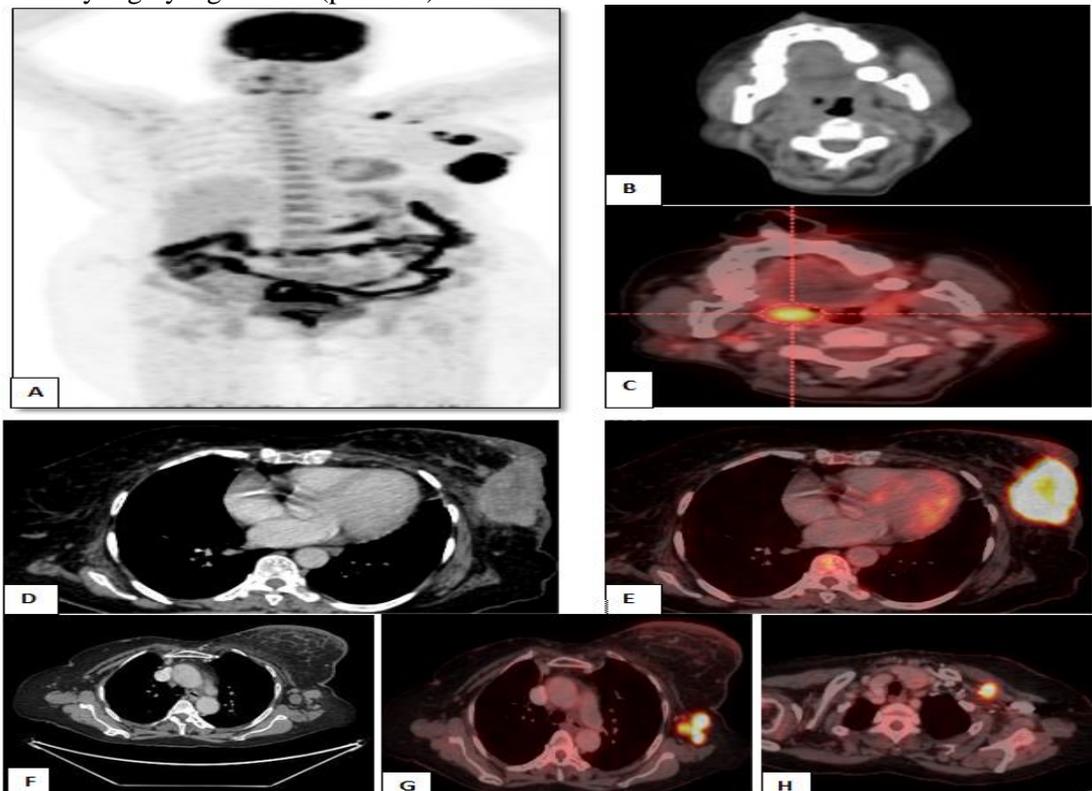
A65 year old female patient presented with newly diagnostic left breast cancer (IDC). A: PET MIP picture of entire body indicated active lesions in left breast and left axilla. B&C: Axial CECT and Fused PET/CT scans respectively indicated few hypermetabolic right submandibular and right lower deep cervical enlarged lymph nodes, the most active is measuring about 15×14mm and achieved up to 5.6SUVmax, not appreciated in CT image alone. D&E: Axial CECT and fused PET/CT scans respectively revealed ill-defined hyper dense soft tissue mass lesion lower outer quadrant of left breast. indicated active ill-defined heterogeneous soft tissue mass lesion with infiltrating the overlying skin and inseparable from underlying pictorialize muscle with related parenchyma distortion and fat planes stranding as well as internal foci of calcification it measures about 8.5x4.6x7.5cm at its maximum dimension and achieves up to 19.4SUVmax.associated thickened overlying skin and subcutaneous edematous changes. Other tiny metabolically active hyper dense subcutaneous nodule closely related to upper aspect of previously described lesion is seen measuring about 6mm and achieving up to 3.9 SUVmax. F,G&H: Axial CECT and fused PET/CT scans of the chest revealed multiple hyper metabolic enlarged left axillary as well as left retro-pectoral lymph nodes (not appreciated on conventional CT), the largest and most active one is measuring about. 2.2x 2cm and achieving up to 13.4 SUVmax....The patient was staged IIIA (T3 N2 M0) by conventional CT and upstaged into IIIC (T4 N3 M0) by PET CT .
